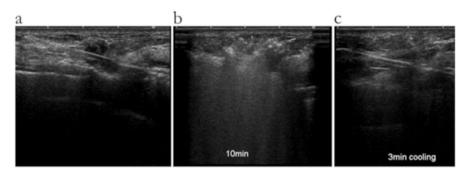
Intraoperative breast ultrasound. (a) Before RF ablation. (b, c) 3-min cooling after RF ablation
